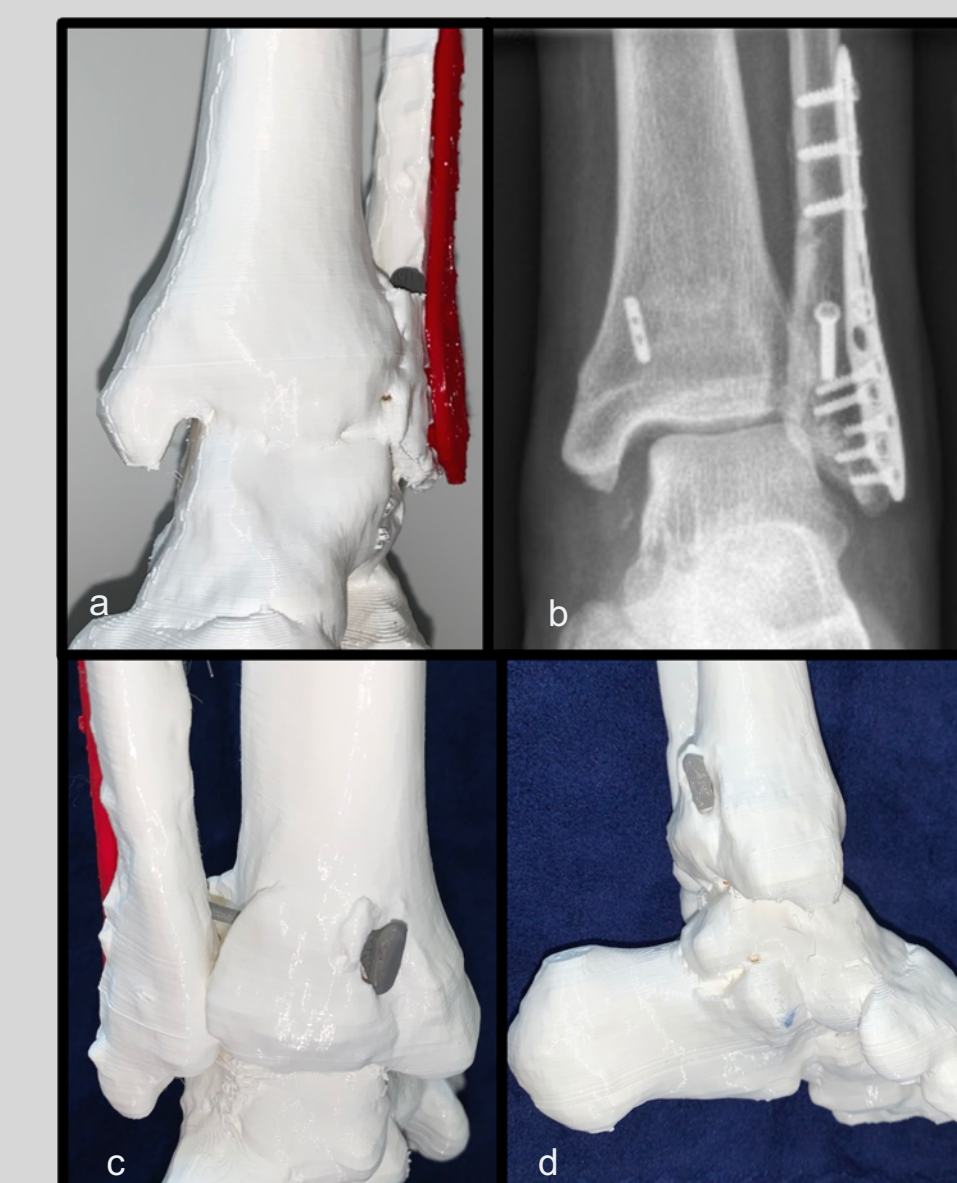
a. Frontal view of the 3D model showing widening of medial clear space. b: AP ankle radiograph with malposition of the syndesmotic fixation. c: posterior view of ankle joint with mal-positioned posterior malleolus. d. Medial view of ankle on 3D model.
